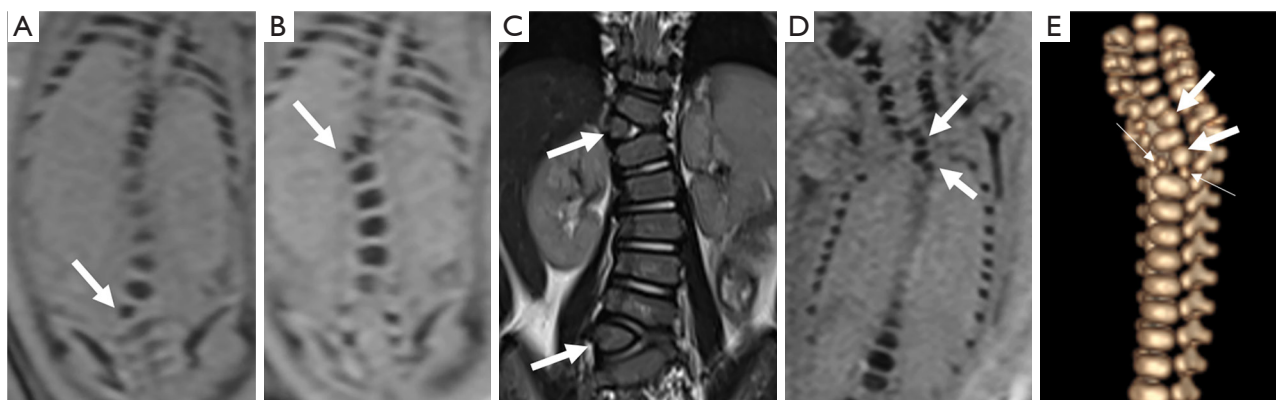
Multiple vertebral anomalies. (A-C) Case 106, L5, T11 hemivertebra at 27 weeks in prenatal coronal SWI images (A, B, arrows), consistent with postnatal coronal T2WI (C, arrows) at 20 months; (D-E) Case 118, C6, T1 hemivertebrae were diagnosed in prenatal coronal SWI at 25 weeks (D, E, thick arrows) and missed diagnosis of T2 butterfly vertebra, which displayed in postmortem CT (E, thin arrows). SWI, susceptibility-weighted imaging; T2WI, T2-weighted imaging; CT, computed tomography.
